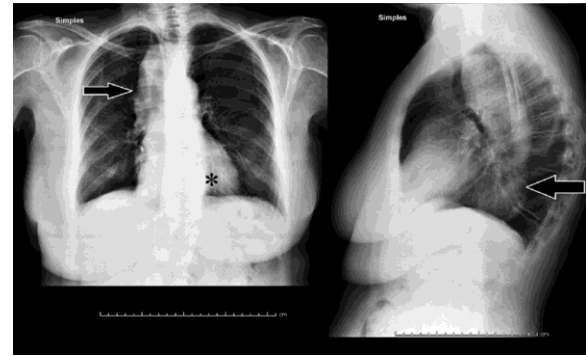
an erect chest X-ray for a patient with achalasia showing a widening in the mediastinum and the absence of a gastric bubble.
